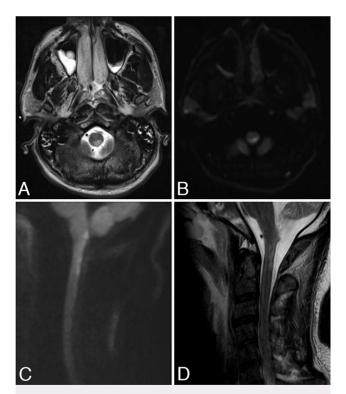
MRI, axial (A, B) and sagittal (C, D) views, with abnormal T2 prolongation (A, C) and diffusion-weighted imaging restriction (B, D) at the dorsal cervicomedullary junction and upper cervical cord concerning for a subacute stroke.
